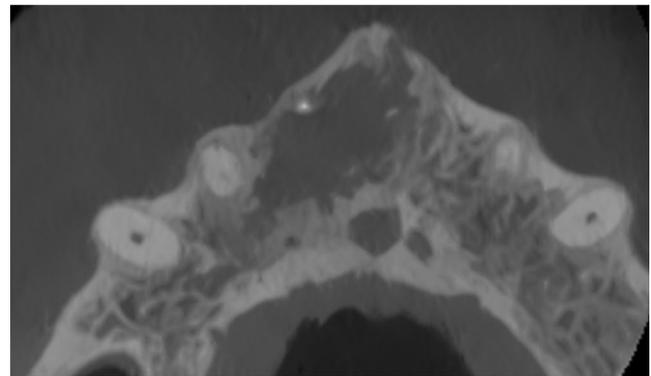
Axial slice of CBCT of Tooth #8 9 months after decompression device removed showing radiolucency separating from Teeth #7 and #9.
